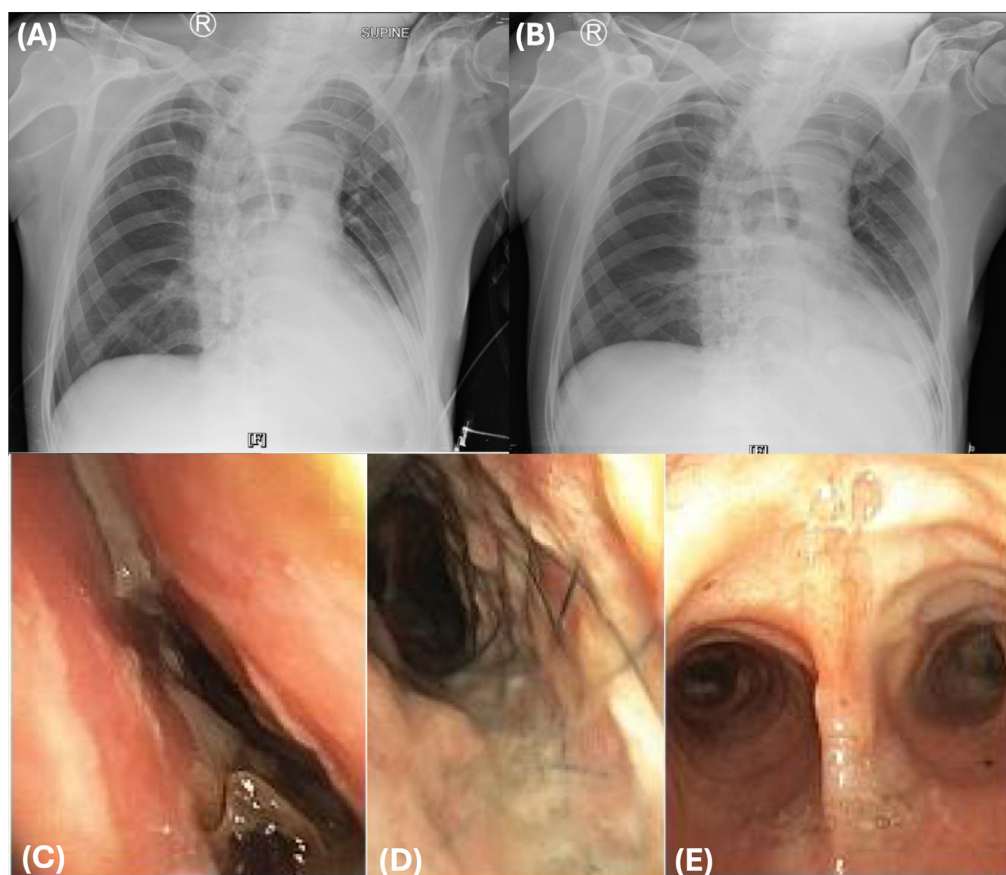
Imaging and bronchoscopic findings in tracheal stenosis treated with balloon dilatation and airway stenting in Case 3. (A) Pre-procedural chest radiograph demonstrating left-sided opacity with features consistent with airway obstruction and associated lung collapse. (B) Post-procedural chest radiograph showing partial re-expansion and improved aeration following airway intervention. (C) Bronchoscopic view before intervention demonstrating severe tracheal narrowing, with a slit-like lumen due to external compression. (D) Intra-procedural bronchoscopic image showing bronchial stent placement within the stenotic airway segment. (E) Post-intervention bronchoscopic view demonstrating improved airway patency, with a widened and more symmetric lumen.
